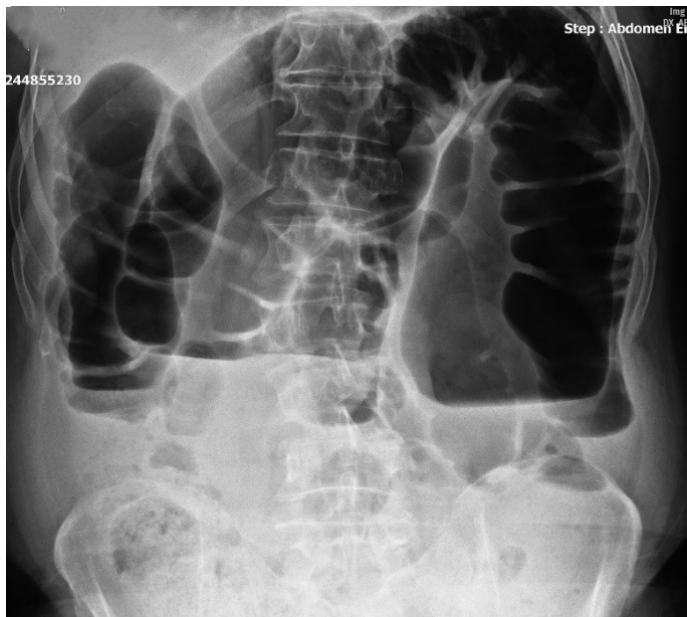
Volvulus Standing Direct Abdominal Radiograph
